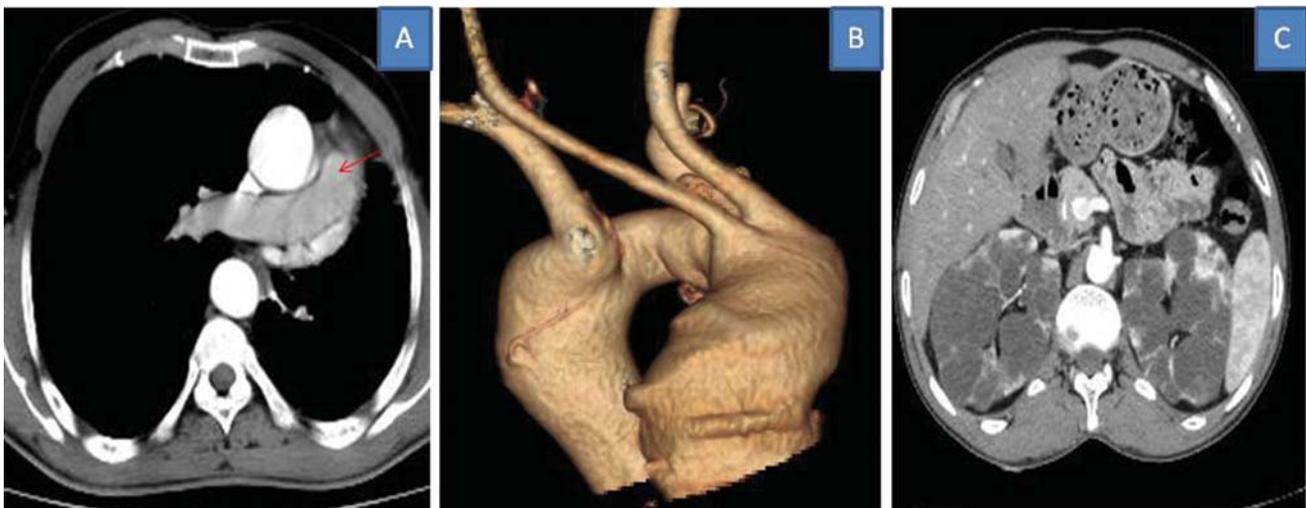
Axial CT thorax showing (A) absence of left pulmonary artery (arrow shows right pulmonary artery); (B) 3D-reconstruction image showing right-sided aortic arch and four branches arising from it; and (C) enlarged bilateral kidneys with multiple cysts and thinning of parenchyma.
